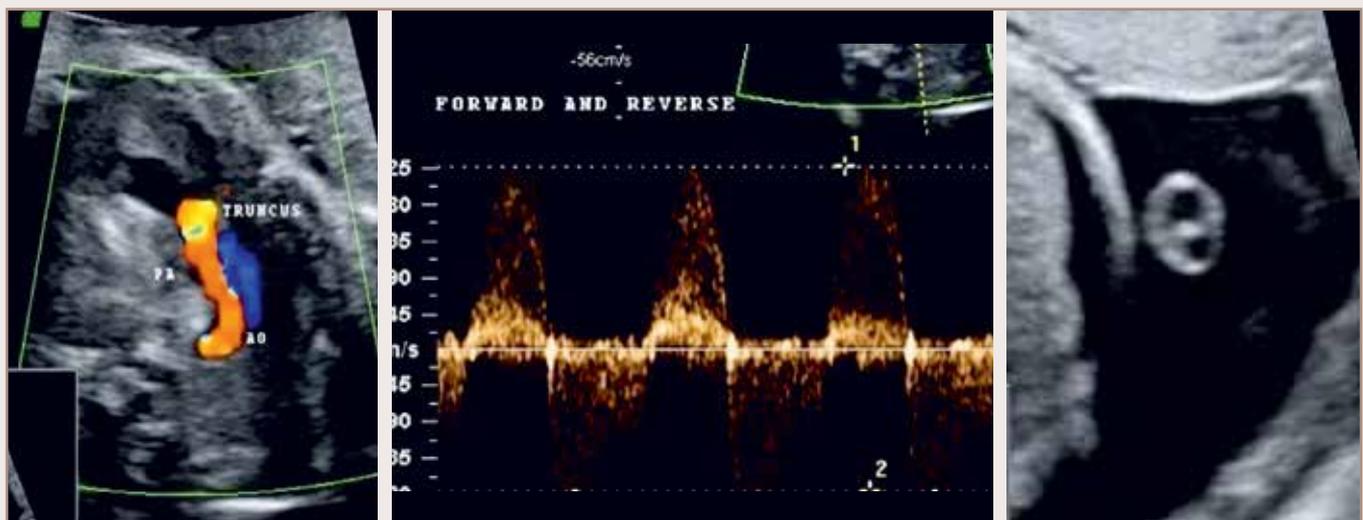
Antenatal Sonography Shows Truncus in Colour with Forward and Reversed Flows /in 2D/Single Umbilical Artery
